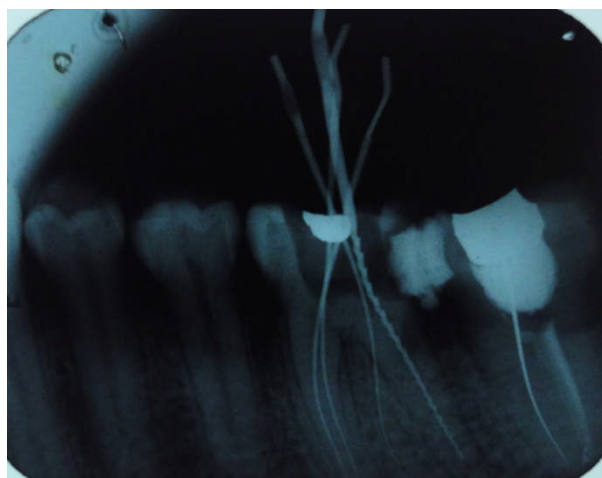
Radiograph showing working length of case 2
